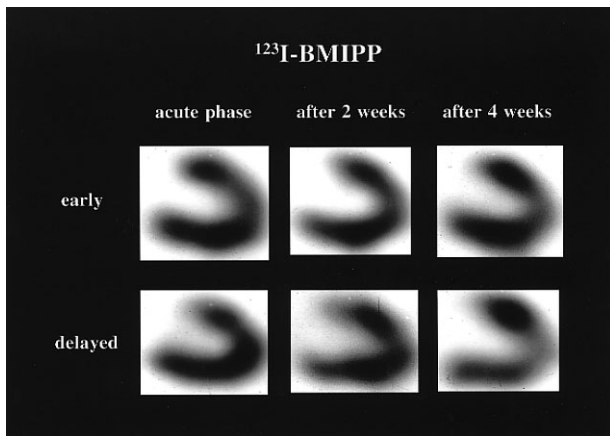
Serial change of ^{123}I -BMIPP myocardial SPECT. ^{123}I -BMIPP myocardial SPECT showed mildly reduced uptake in the anteroapical wall and the apex on the early images, but on the delayed images these findings were improved. After medication ^{123}I -BMIPP myocardial SPECT findings improved, but the washout of ^{123}I -BMIPP from myocardium accelerated.
